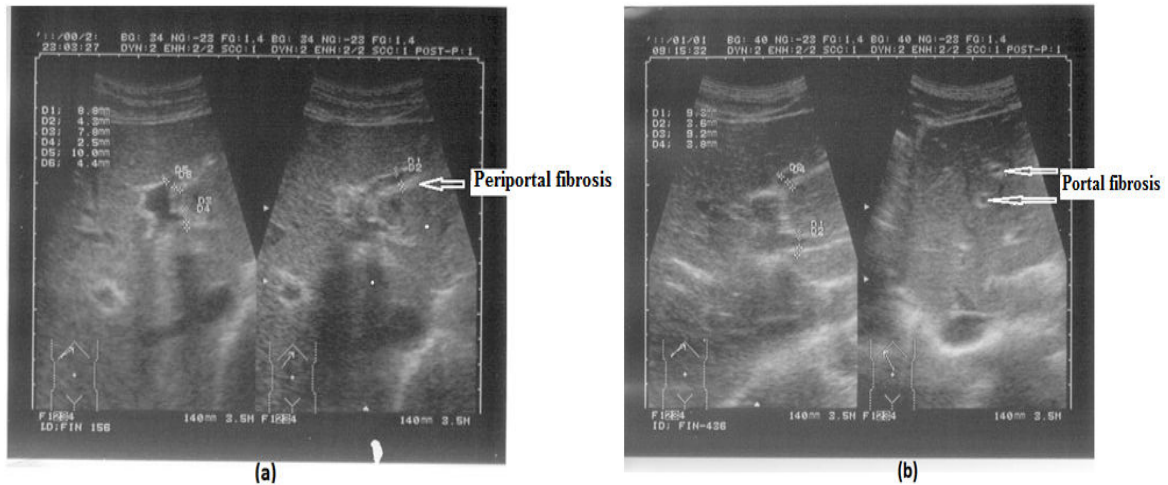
Ultrasonographic images in hepatic schistosomiasis: (a) Periportal fibrosis (Grade C Mild fibrosis) (b) Portal fibrosis (Grade D moderate fibrosis) among study
